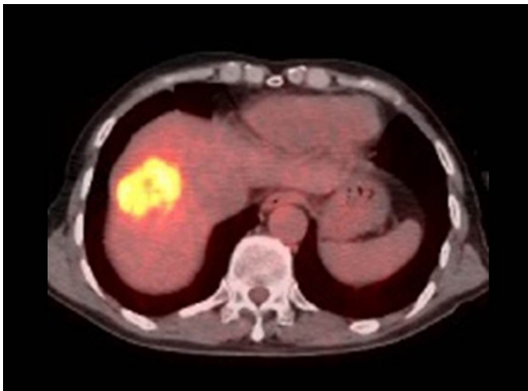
Positron emission tomography with computed tomography (PET-CT) (SUVmax 14.6).
